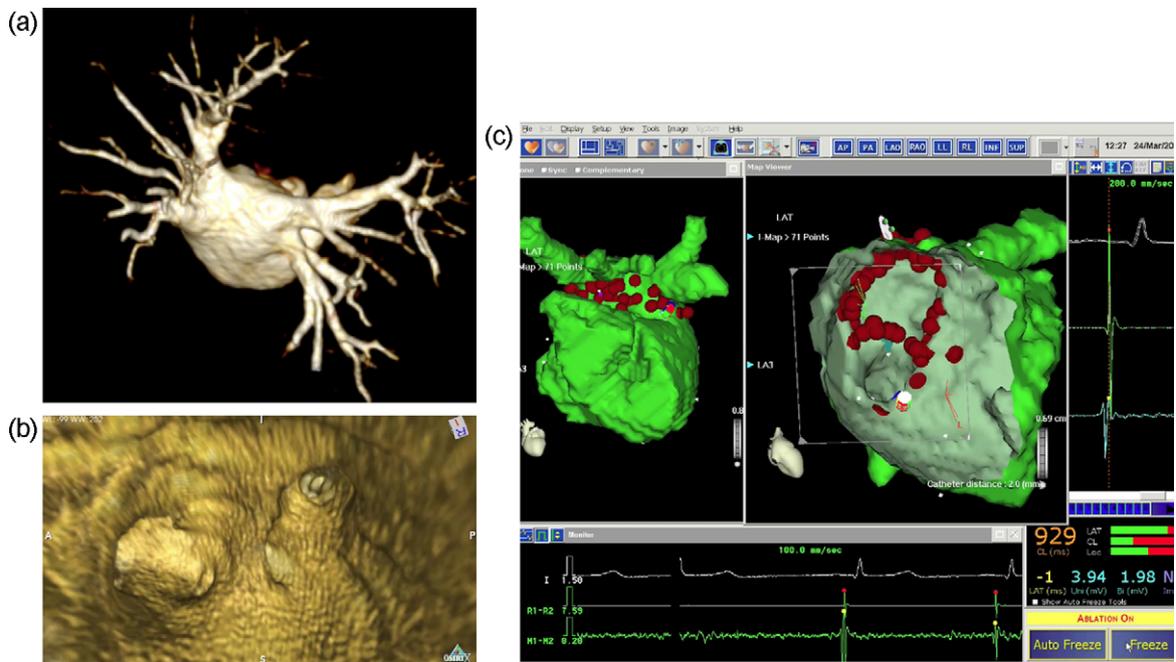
Real-time MRI-guided percutaneous ablation of atrial fibrillation. Volume Rendering (a) and Virtual Endoscopy (b) reconstructions give the interventional cardiologist a realistic depiction of the left atrial anatomy, and (c) real-time image fusion between pre-procedural MRI and intraprocedurally obtained electrophysiological map allow him to safely navigate inside the left atrium, with a reduced risk of interventional complications and a dramatic decrease of radiation exposure due to reduced need for fluoroscopic guidance.
